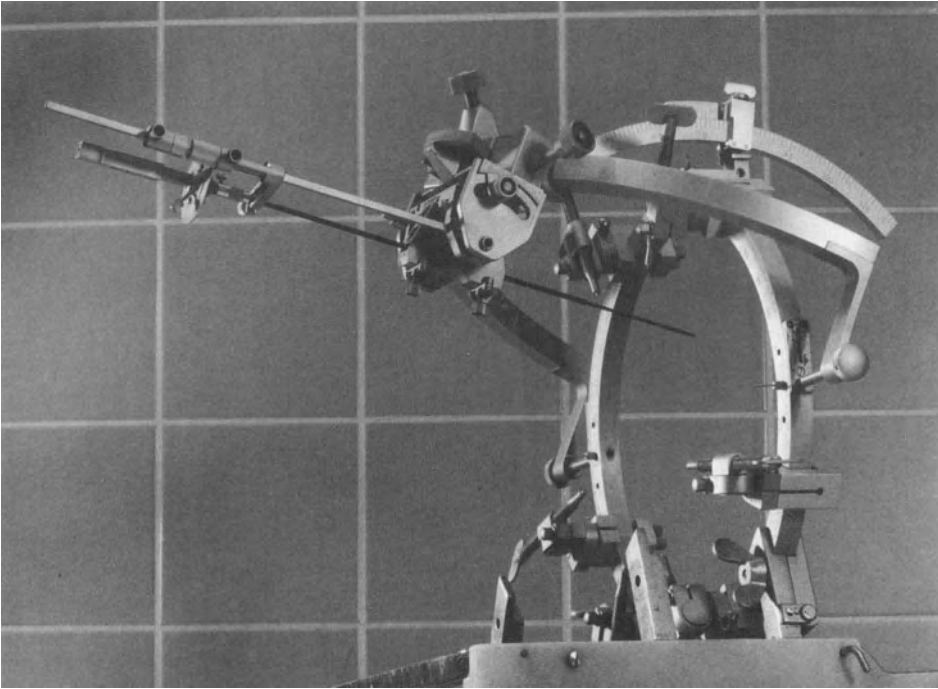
The Reichert-Munding stereotactic device in its computer-compatible version, designed by the authors. The target arc is fixed on the base ring by a segmental arc. For radiographic imaging, the ring is positioned on a fixation device on the operating table.
